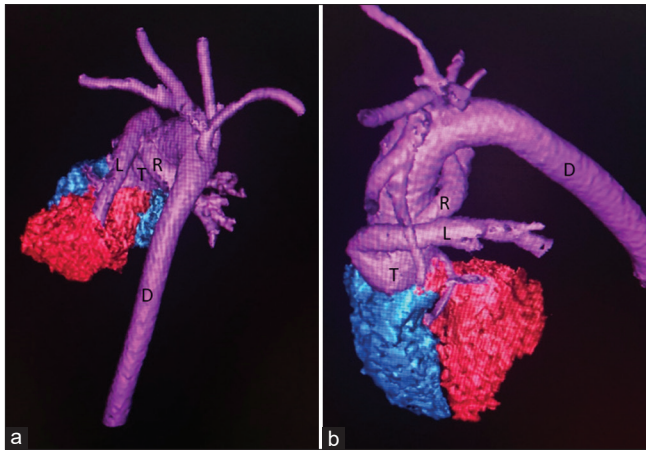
Computed tomographic reconstructed images. (a) Posterior view of the heart. (b) Left lateral view. T: Truncus arteriosus, L: Left pulmonary artery, R: Right pulmonary artery, D: Descending aorta
